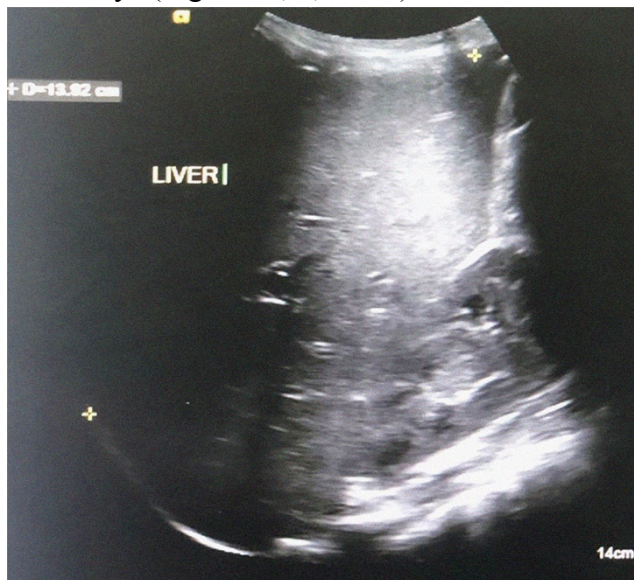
Ultrasonography of abdomen showed hepatosplenomegaly with innumerable focal lesions.
